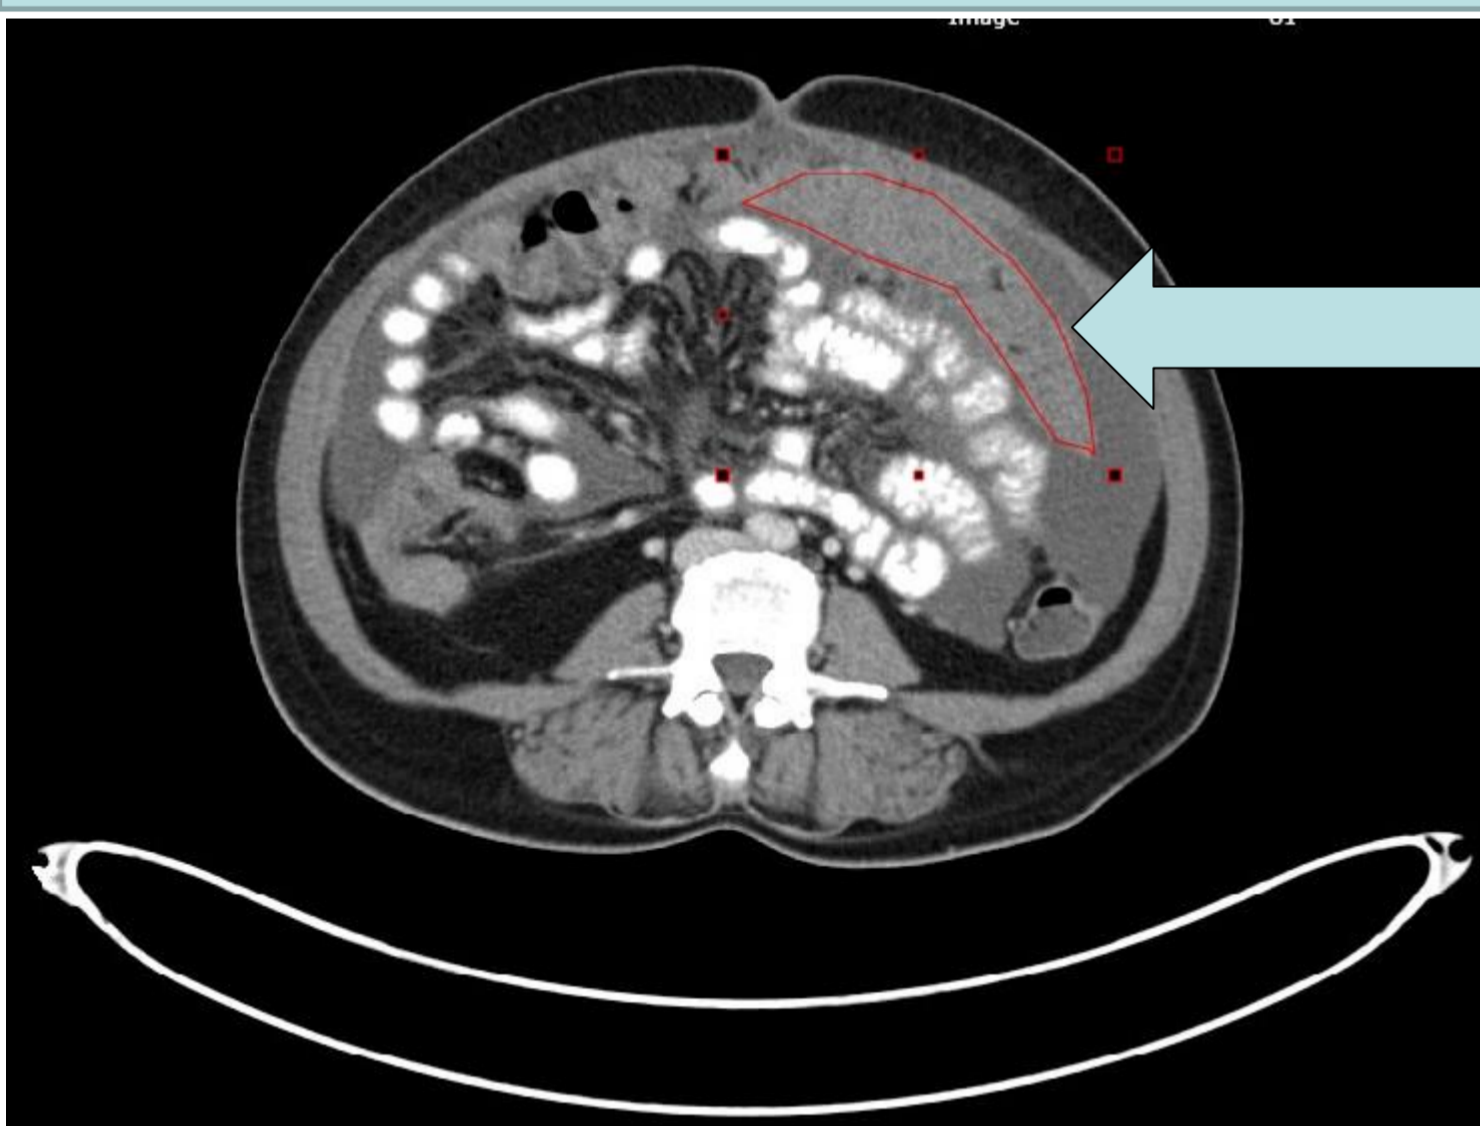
Region of interest (ROI) was drawn on CT Contrast image.
